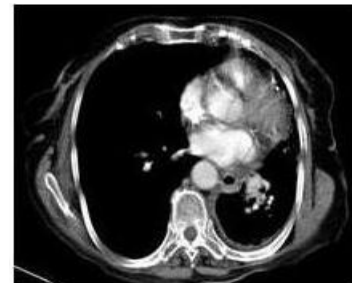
Thorax CT showing left lung atelectasis.
